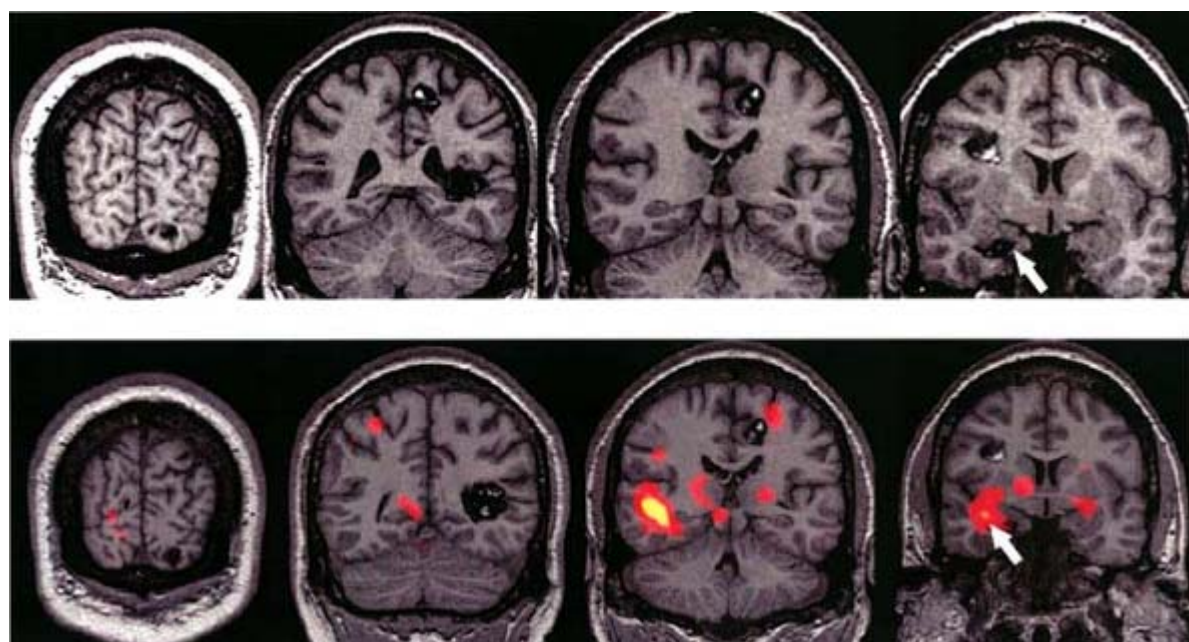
Coronal MRI (magnetic resonance imaging) (*top row*) and subtraction ictal SPECT (single photon emission computed tomography) coregistered to MRI (SISCOM) (*bottom row*) images of a patient who had medically refractory partial epilepsy associated with multiple cavernous angiomas. Electroencephalography did not localize seizure onset. SISCOM shows ictal hyperperfusion focus at the right mesial temporal angioma, and seizure semiology was compatible with right temporal onset seizures. Resection of the right temporal angioma and its immediate surrounding tissues resulted in seizure freedom. (See black and white image.)
